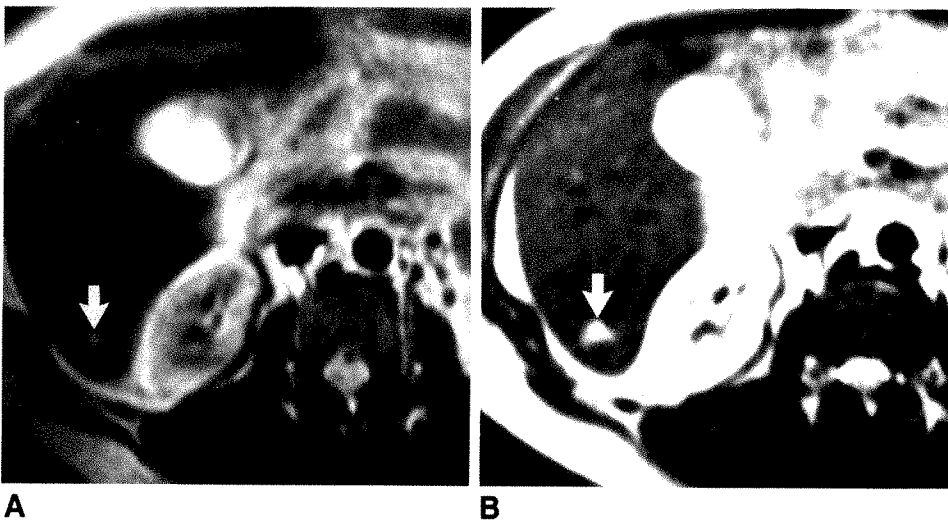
T2-weighted MR images (2000/70, 256 × 128 matrix, four excitations) of a presumed liver hemangioma.
